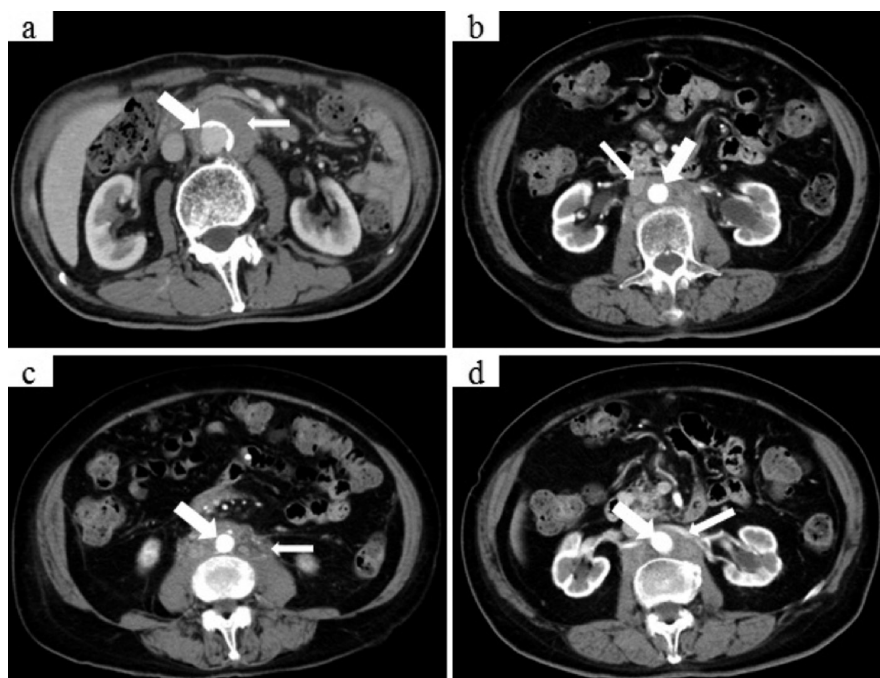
CT scan of the abdomen with intravenous contrast. (a) Large arrow indicates aorta, small arrow indicates soft tissue surrounding aorta. (b) Aorta (large arrow) and soft tissue surrounding inferior vena cava (small arrow). (c) Aorta (large arrow) and soft tissue surrounding the ureter (small arrow). (d) Aorta (large arrow) and soft tissue surrounding left renal vein (small arrow).
